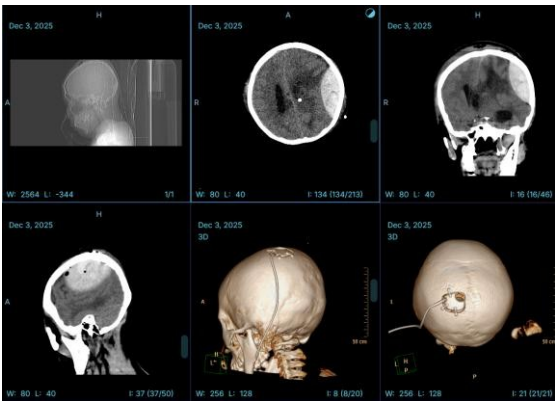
CT scan of the head dated December 3, 2025
